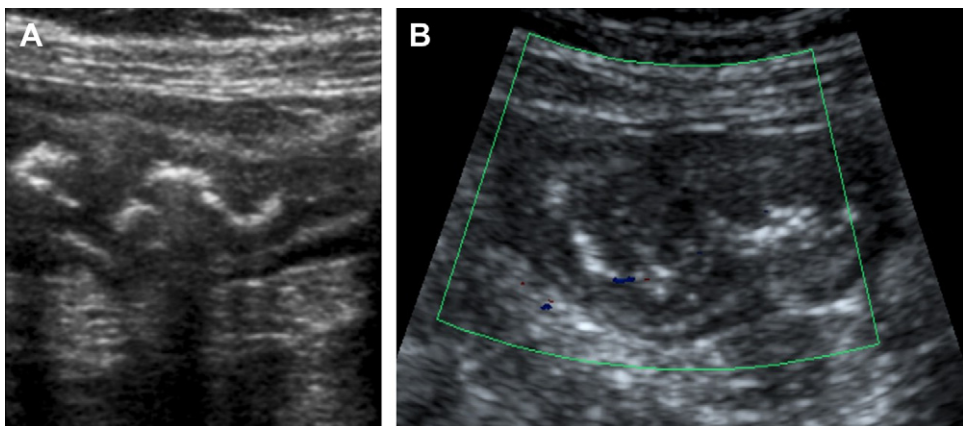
(A) An elderly man sent to US for nonspecific abdominal pain post total knee replacement; thickening of the right colon was associated with tenderness. (B) No Doppler signal obtained despite maximizing parameters concerning for ischemia rather than inflammation. CT scan performed. Ischemia confirmed at surgery.
